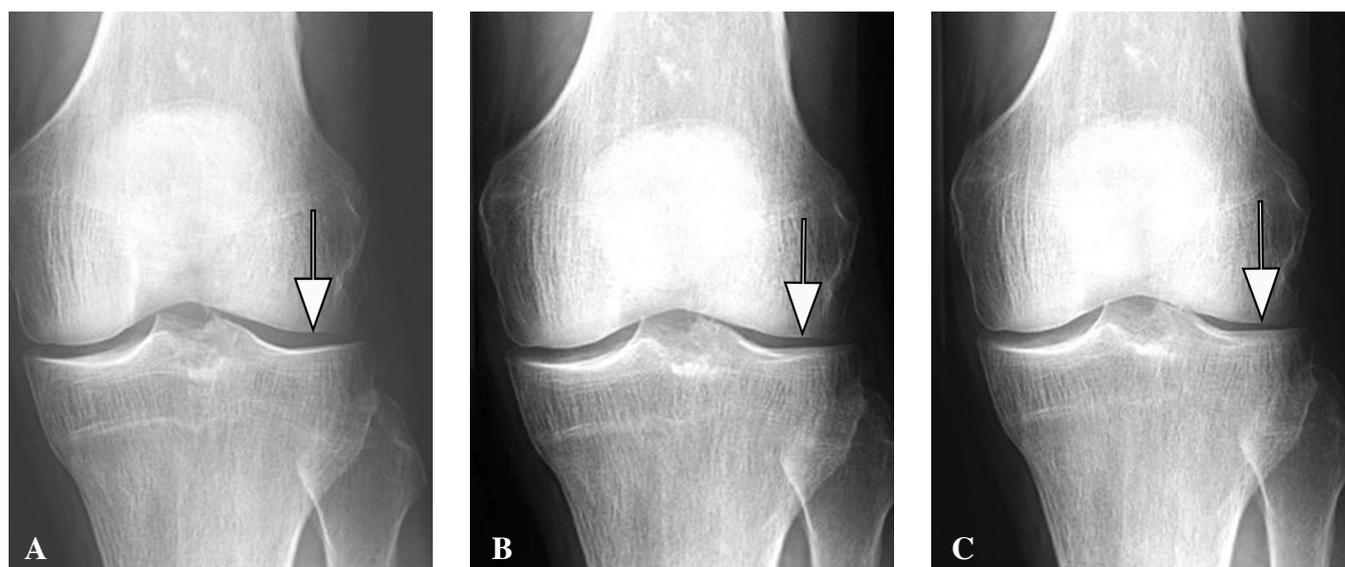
Positioning challenges using radiography. Serial radiographs of the same knee acquired consecutively.
